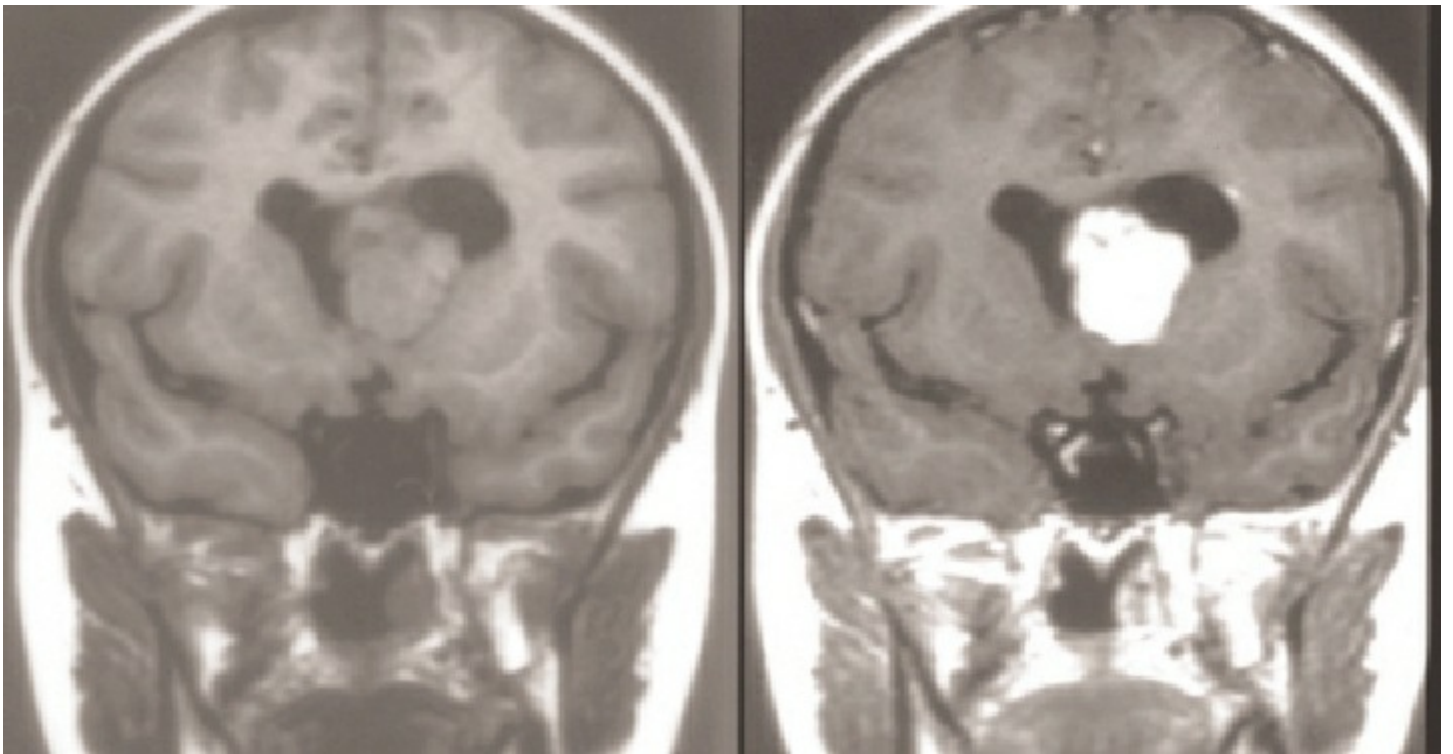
Pre and post-contrast coronal MRI showing an SGCT enhancing brightly. This is the same patient as above.
